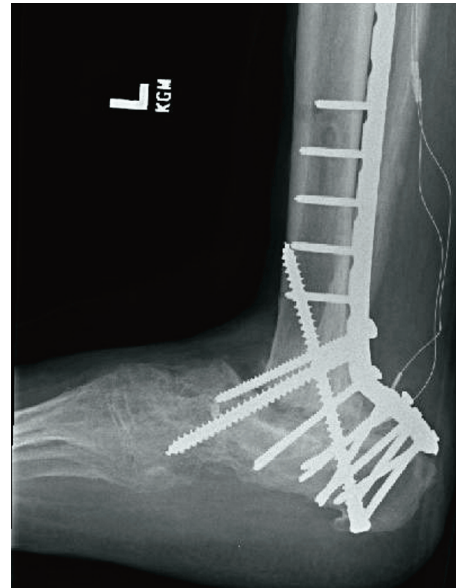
Postoperative radiograph shows the subtalar joint has been fused with internal fixation consisting of a plate and screws. A relatively large amount of fixation was used due to the patient's diabetic charcot arthropathy.
